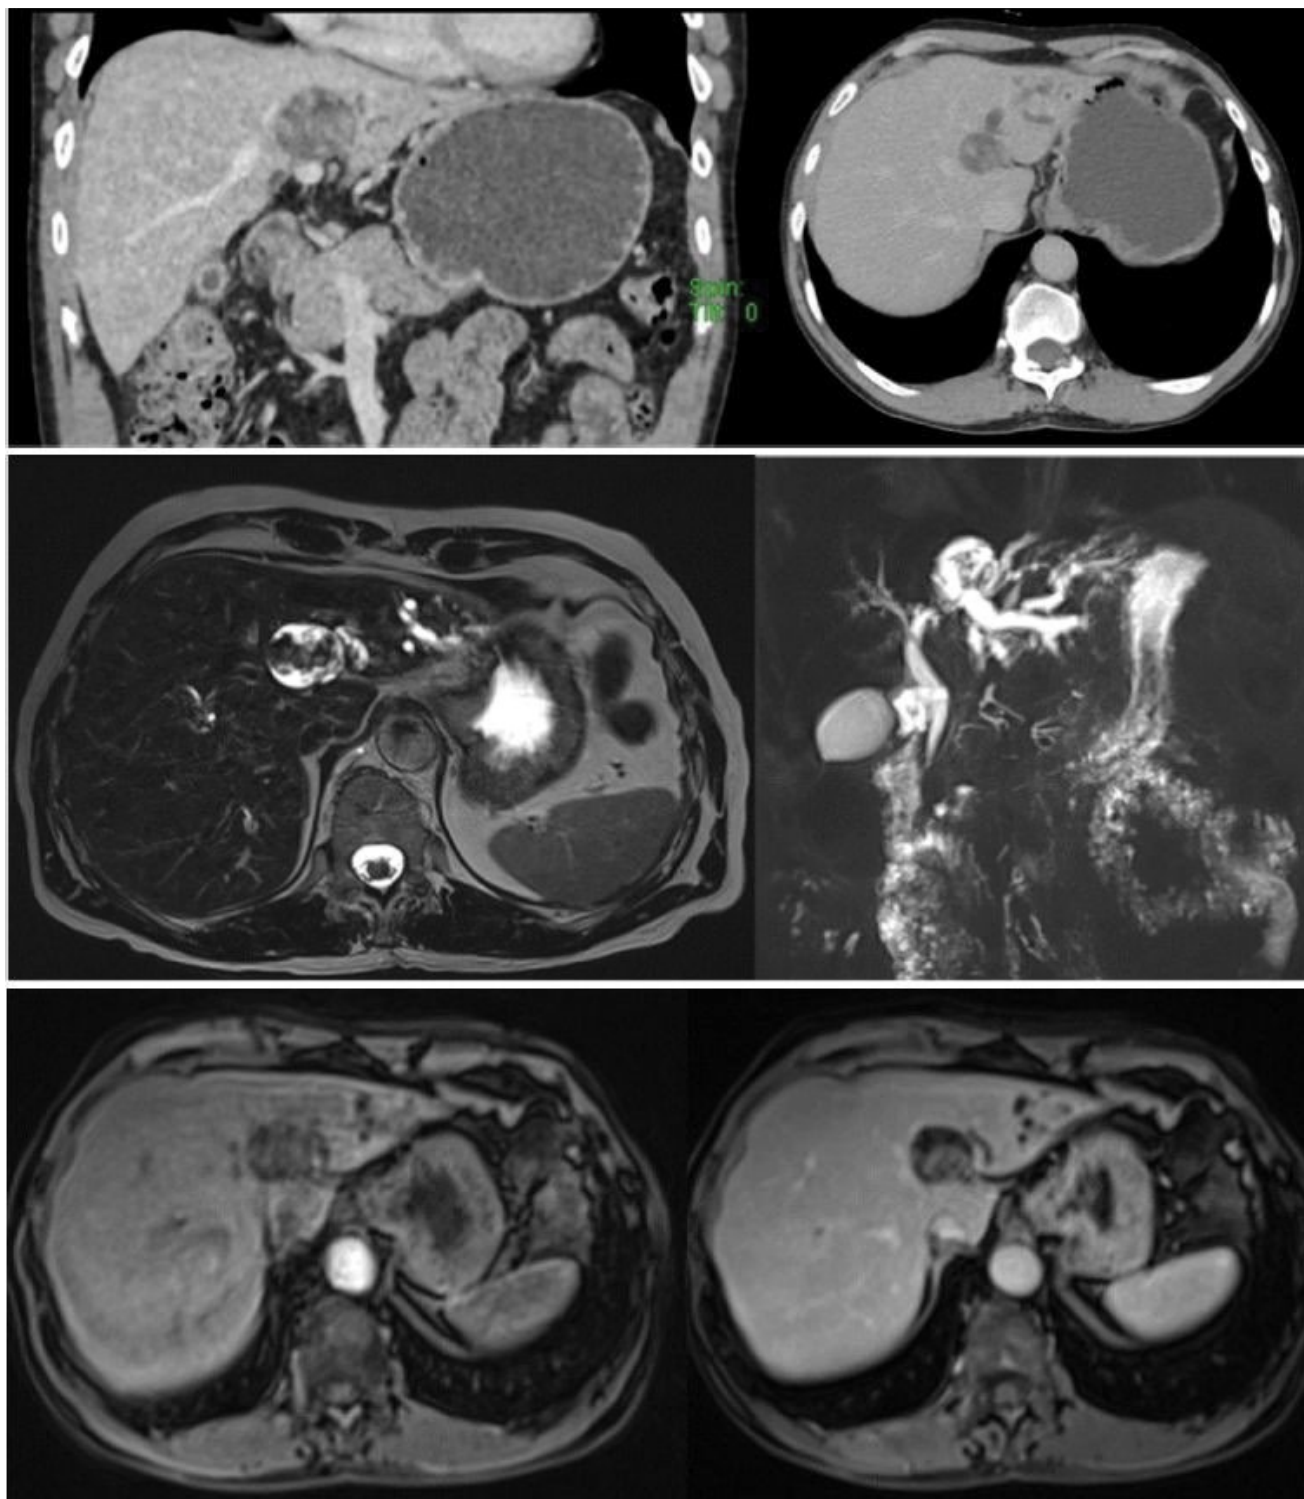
IPMN-B. (a,b) Contrast enhanced CT coronal (a) and axial section (b) shows a cystic lesion in the segment 4 of liver with enhancing intra-cystic solid areas. Lesion appears to be in contiguity with upstream dilated biliary radicles in the segments 2 & 3 of liver; (c,d) MRI-T2 SPACE 3D axial section shows T2 hyperintense cystic lesion with hypointense solid areas within the lesion and upstream biliary radicle dilatation. (e,f) MRCP images shows cystic lesion in continuity with left hepatic duct causing upstream biliary radicle dilatation; (e,f) Post contrast T1 VIBE axial sections shows hypoenhancing solid areas in the arterial phase (e) which progressive increase in enhancement in the portal venous phase (f).
